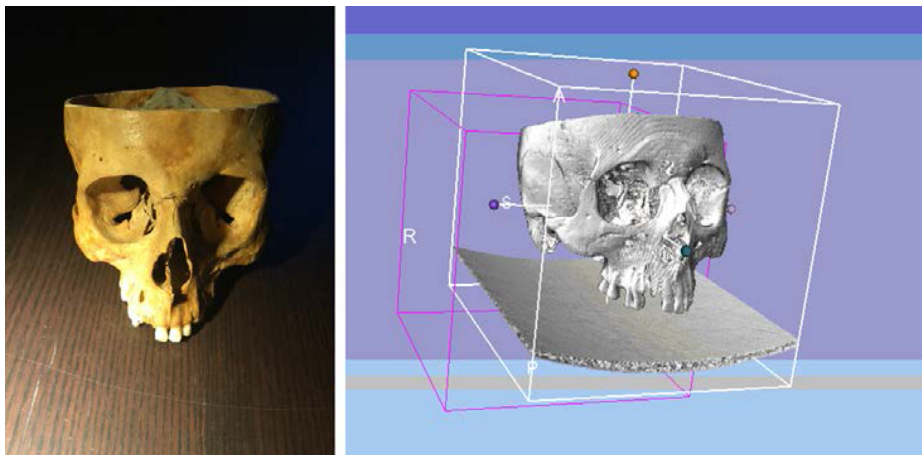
A skull and its model reconstructed basing upon CT imaging
